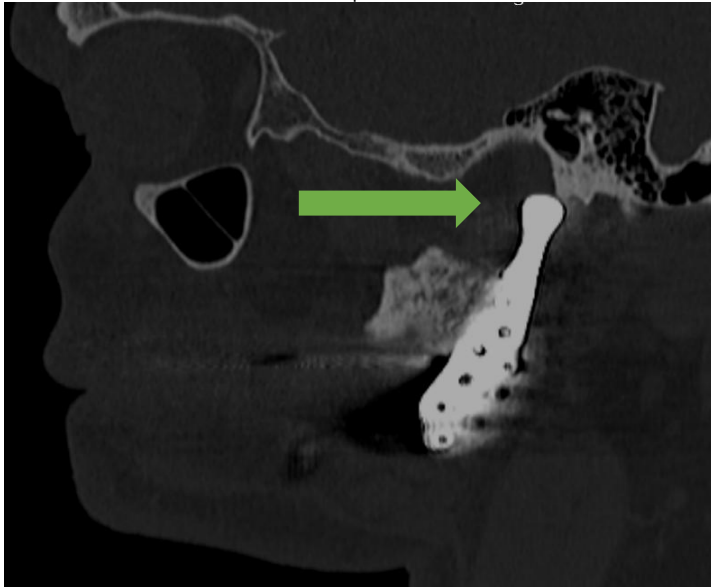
Computed tomography scan, sagittal view. Displacement of the implant (green arrow). Radiological examination was performed 2 months after the surgery (RadiAnt DICOM Viewer 2025.2).
